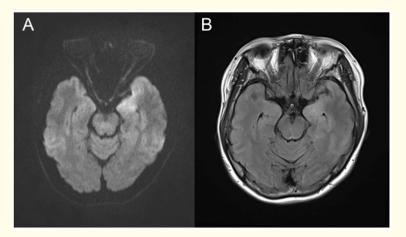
Brain MRI at time of initial presentation, including (A) diffusion-weighted and (B) fluid-attenuated inversion recovery (FLAIR) images.
